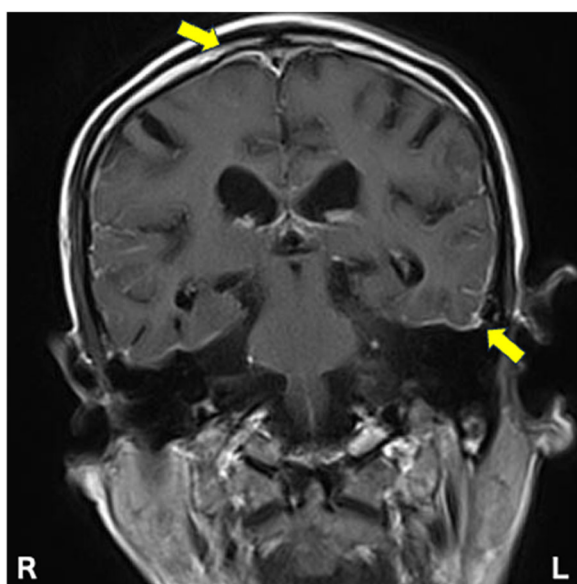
A coronal T1-weighted gadolinium-enhanced magnetic resonance imaging (MRI) revealed pia-arachnoid pattern thickened and enhanced dural (yellow arrows).
